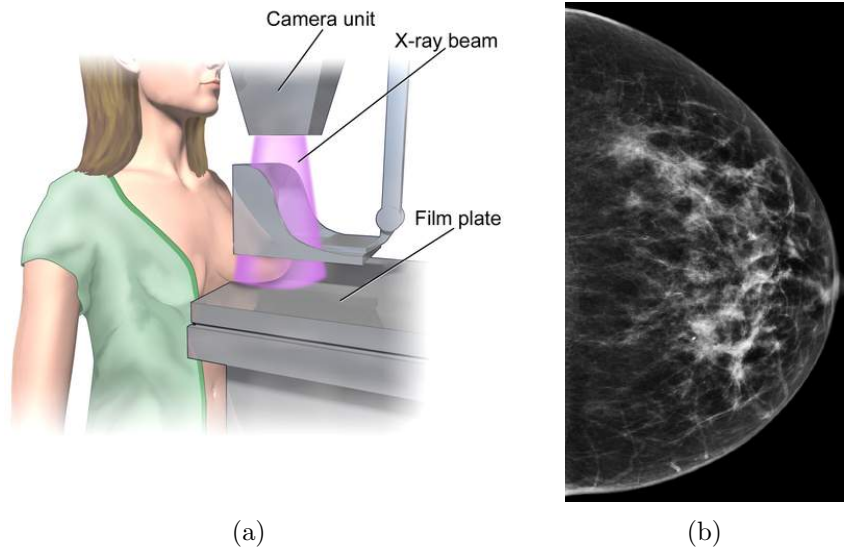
Mammography. (a) Data acquisition. (b) Example of x-ray attenuation image.
